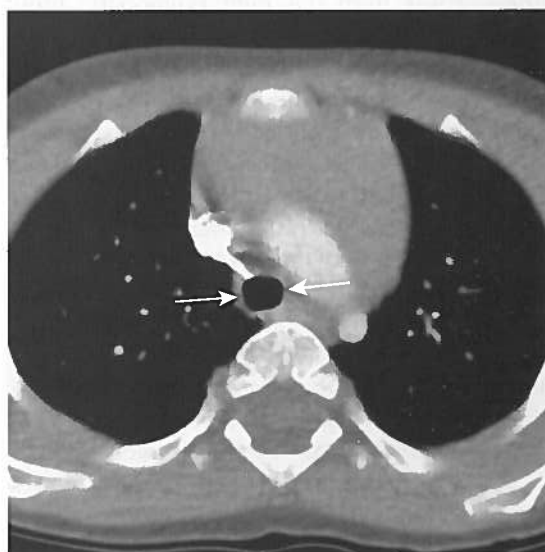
Bronchogenic cyst causing compression of left main bronchus. A, Chest radiograph showing left lower lobe, retrocardiac density, and asymmetric hyperlucency of left upper lobe. Similar findings were present on radiography on multiple occasions. B and C, CT showing mediastinal (B) and lung (C) windows, which show a well-defined, low-attenuation mass (B), which is consistent with a bronchogenic cyst. The lesion is adjacent to the carina and is compressing the left main bronchus (*arrow*).
